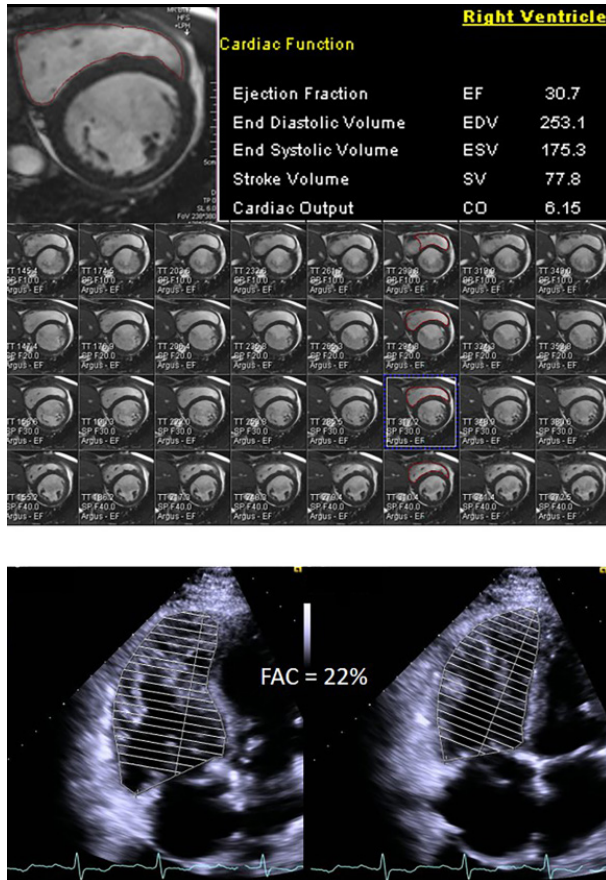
Predictive value of right ventricular function in heart failure. The upper part of the figure shows the CMR approach to measuring right ventricular volumes and ejection fraction. CMR is the recommended method for this purpose. The powerful predictive value of RVEF in patients with left heart failure is shown in the lower half with ejection fraction of $<30\%$ portending a bad prognosis. Echocardiography is the standard and the most common method used to assess right ventricular function in daily practice. RVEF cannot be measured by 2-D echocardiography and several Doppler echocardiography indices are used as a surrogate for RVEF instead.
